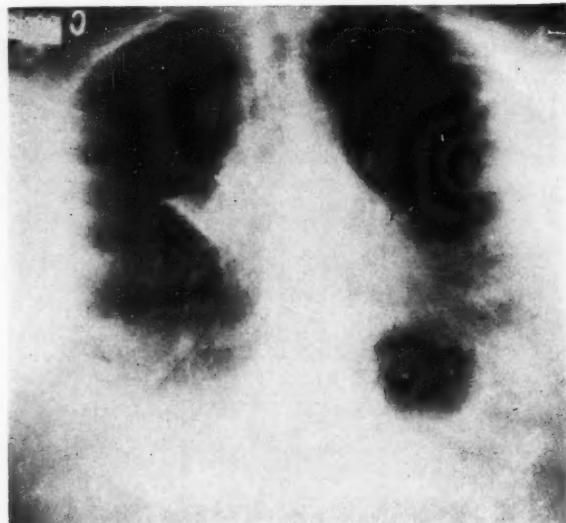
Lordotic position, postero-anterior view, showing the characteristic triangular shadow of a shrunken right middle lobe. A plain film showed a small area of infiltration in the right lower lung field mesially.
